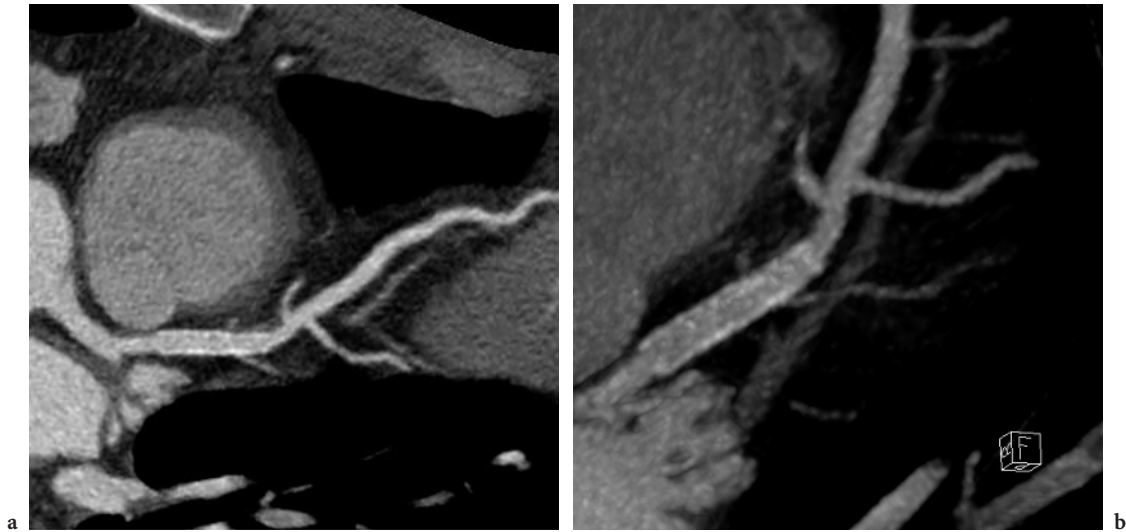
64-slice CT examination of a patient after placement of a drug-eluting stent in the proximal LAD. The low-opaque stent can be visualized with curved MPR (a) and curved MIP (b), with practically unhindered interpretability of the patent vessel lumen. (Case courtesy of Sarawak Heart Center, Kuching, Malaysia)
